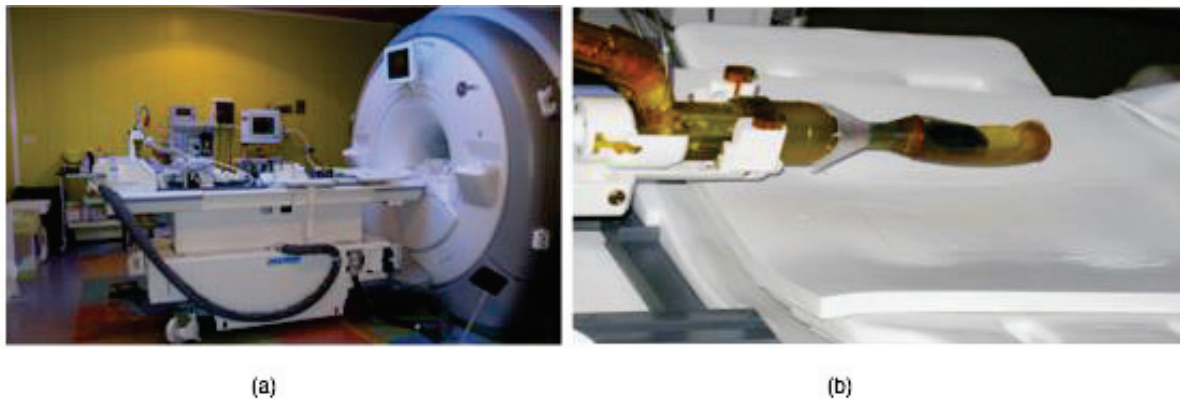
(a) The combined ExAblate 2100 and Discovery MR750 MRgFUS system; (b) the table built-in mechanical insertion arm featuring the 990-elements phased-array focused ultrasound probe for MRgFUS filled with degassed water at 12° C.
